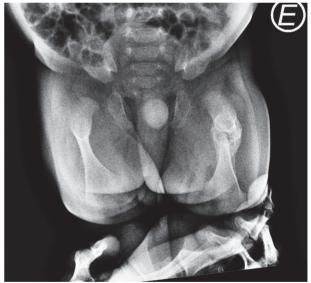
Radiography performed at 1.5 months of life with a consolidated and aligned fracture of the left femur.
